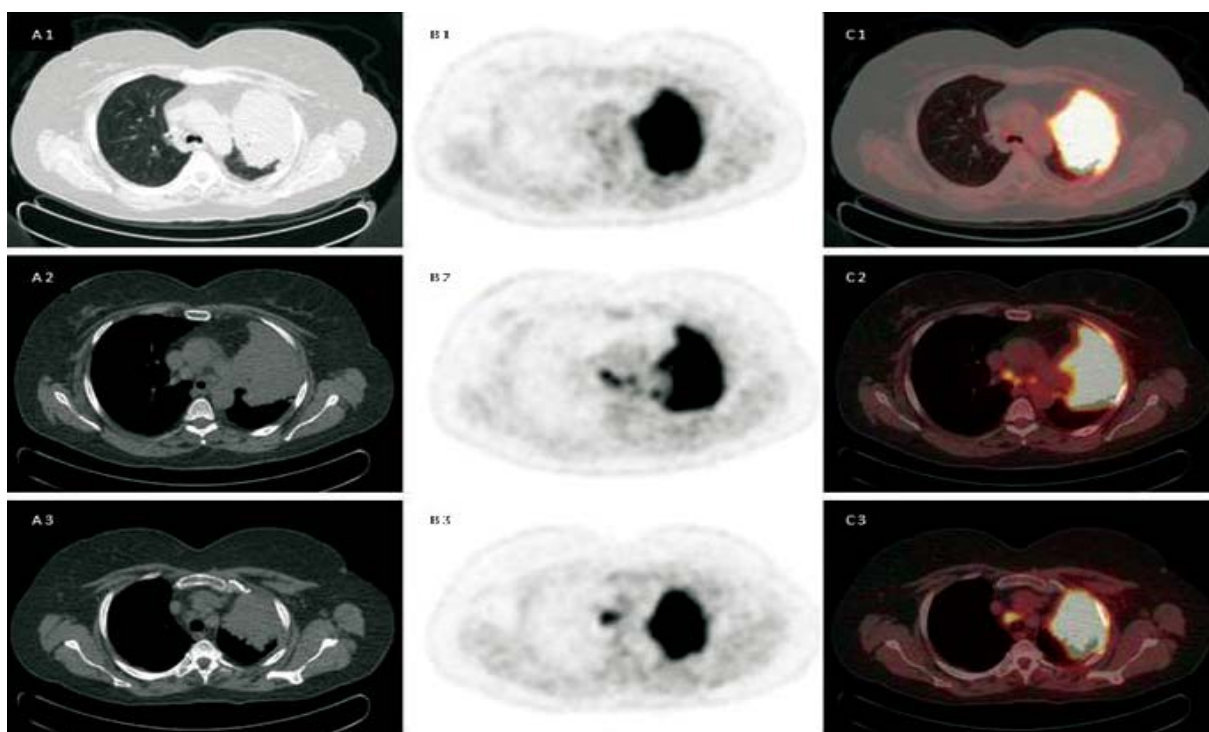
62-year old patient under suspicion of bronchial cancer of the left upper lobe referred for [ $^{18}\text{F}$ ]FDG PET/CT for primary staging. [ $^{18}\text{F}$ ]FDG PET/CT revealed FDG-positive primary tumor and contralateral lymph node metastases (N3); (A 1-3) CT scan, (B 1-3) PET scan, (C 1-3) PET/CT fused images
